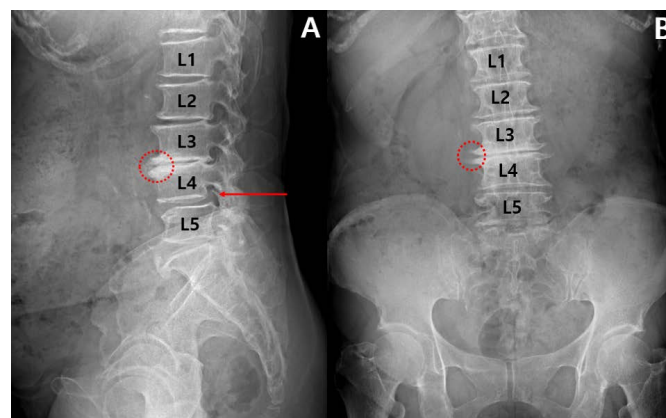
Simple radiography image of the time of onset. (A) Sagittal view. (B) Coronal view. In the sagittal view image, the red arrow indicates a bone spur on the L4-5 level of the intervertebral foramen and it is because of degenerative changes, which causes stenosis of the L4-5 level. The red circle shows the endplate change on L3-4. In the coronal view image, the red circle shows a bone spur on the L3-4 vertebra. *The above images were read by a radiologist as lumbar scoliosis, disc space narrowing, L1-2-3-4-5-S1, degenerative spondylosis.
